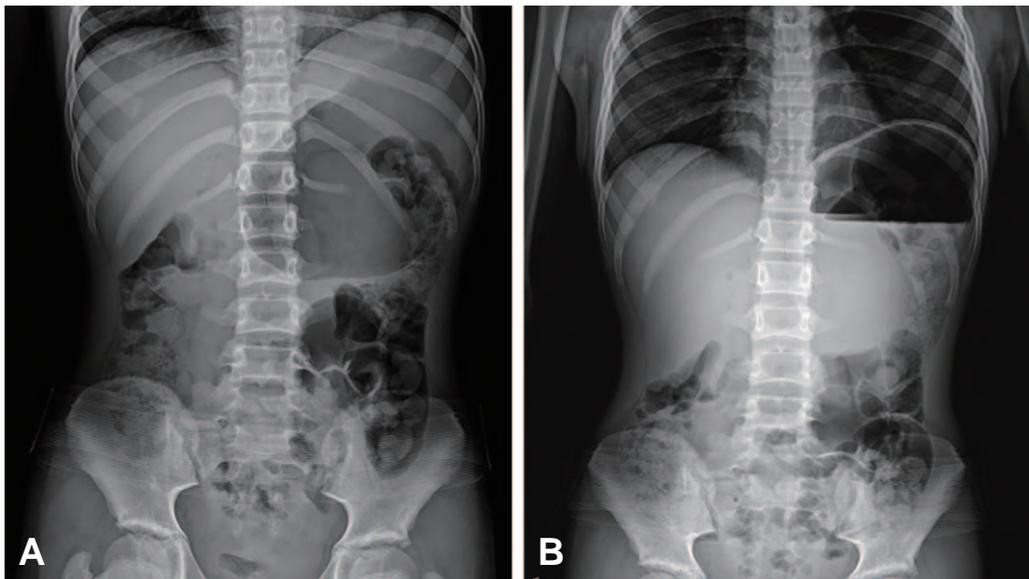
Plain radiographs showing a gastric distension (supine, A) and air–fluid level (upright, B).
